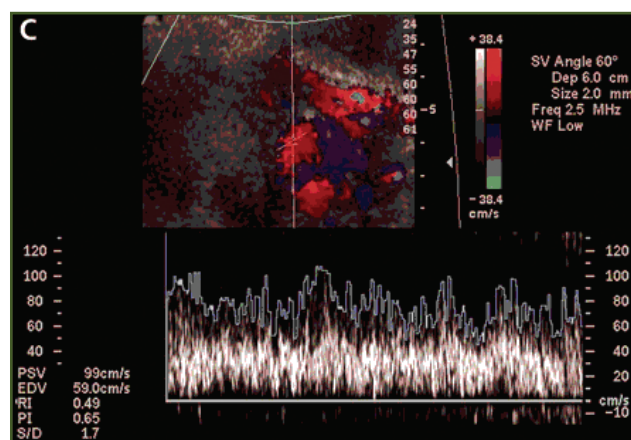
Color Doppler Showing Increased Vascularity
